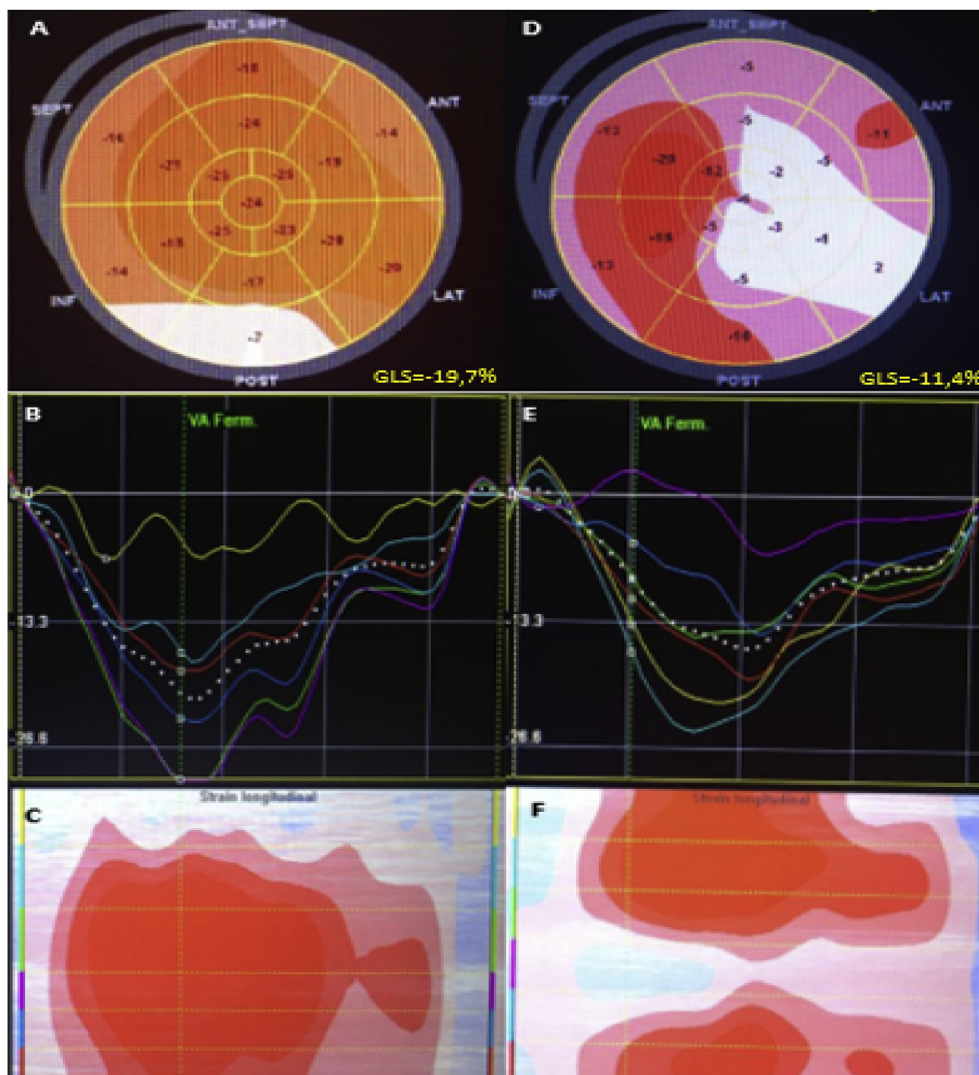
(A, D): Representative bull's-eye displays with segmental peak systolic longitudinal strains; (B, E): Longitudinal strain curves of each segment from the apical two-chamber view; (C, F): Curved anatomic M-mode of the longitudinal strain. Images obtained from selected patients: Panel (A, B, C) of the patient n° 1 with normal GLS at rest at -19.7% with no significant CAD at coronary angiogram and Panel (D, E, F) of the patient n° 2 with decreased GLS at rest of -11.4% with severe CAD.
